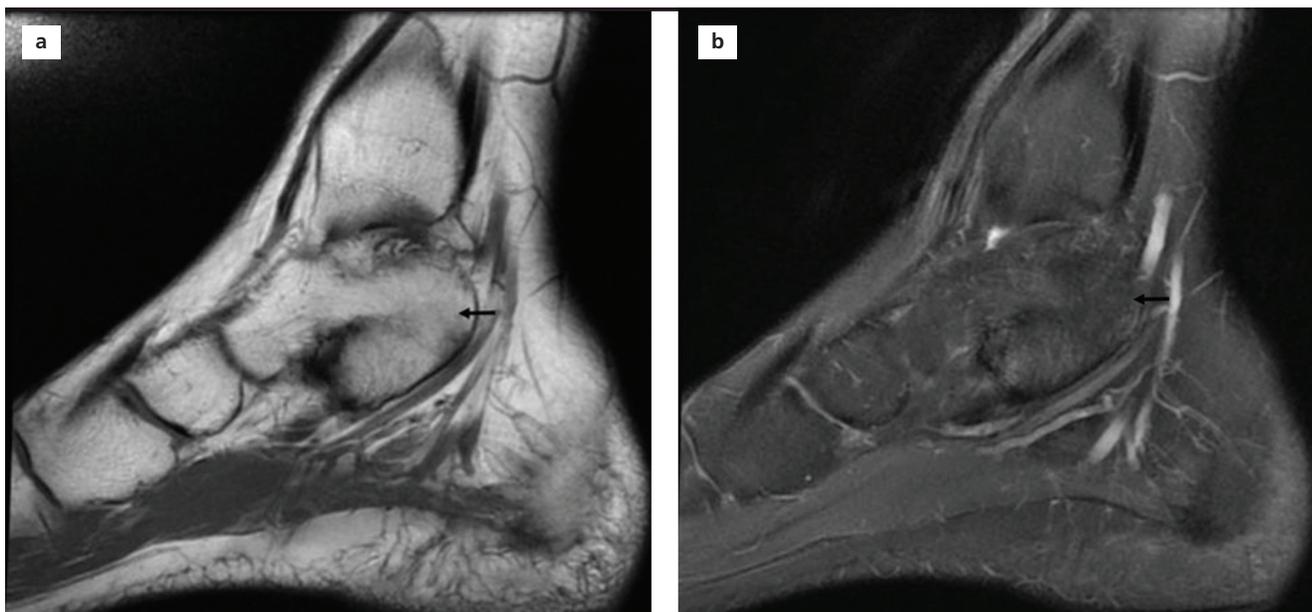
(a) Sagittal T1-weighted and (b) T2-weighted fat-suppressed images through the talocalcaneal joint show bone marrow signal (black arrow) continue across the fused articulation (osseous coalition) in the ankle MR images.
